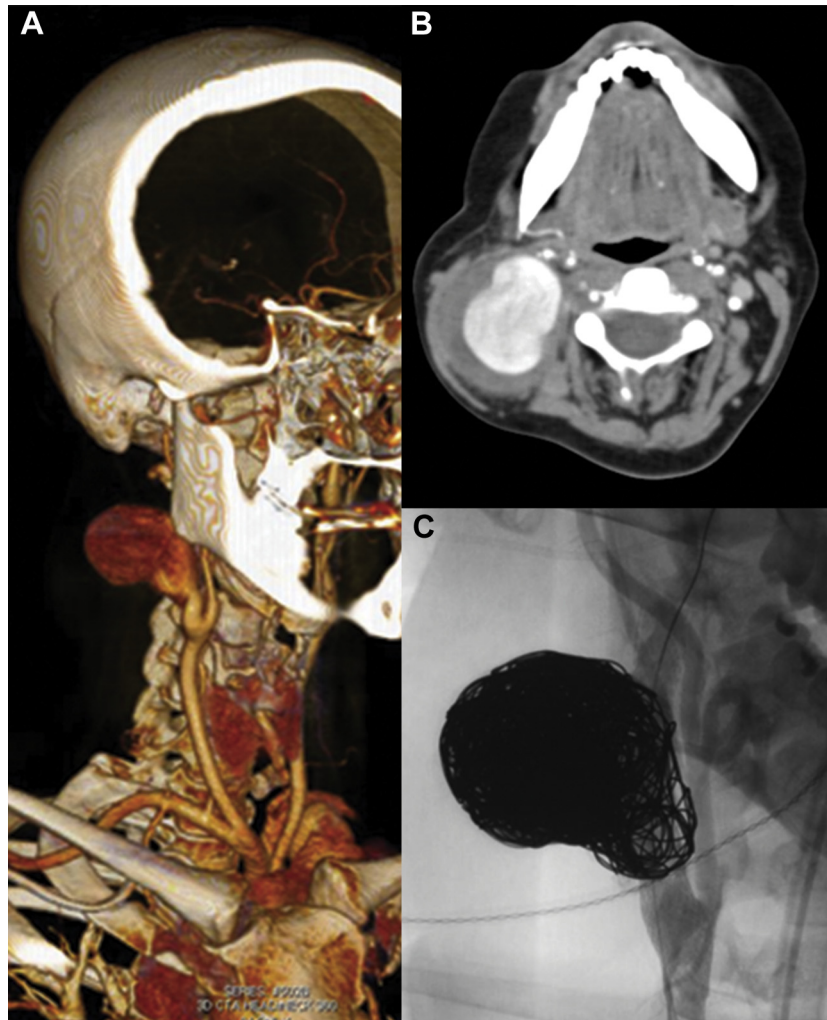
A 6-cm carotid artery aneurysm developed in a 34-year-old woman acutely in the postpartum period. A, A three-dimensional computed tomography (CT) reconstruction and (B) representative axial image of a CT scan demonstrate the large right internal carotid artery aneurysm. Her arterial pathology led to vascular Ehlers-Danlos syndrome (vEDS) diagnosis (MIN mutation, c.1772G>A, p.Gly591Asp) and preoperative multidisciplinary planning accordingly. C, She was successfully treated with stent-assisted coil embolization of the internal carotid artery aneurysm. *MIN*, mutations that lead to minimal (10%-15%) normal type III collagen production. Images courtesy of Johns Hopkins Hospital/National Institutes of Health.
